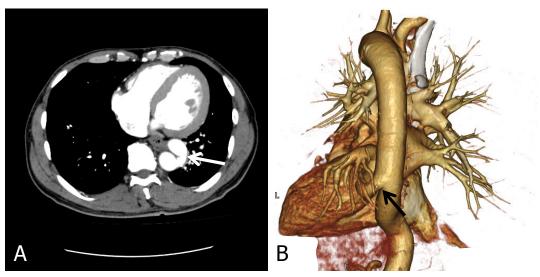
(A) The aberrant artery arises from the descending thoracic aorta (DTA) (white arrow), (B) 3D-CT also shows aberrant artery from DTA (black arrow) and the basal pulmonary artery is not detected.
